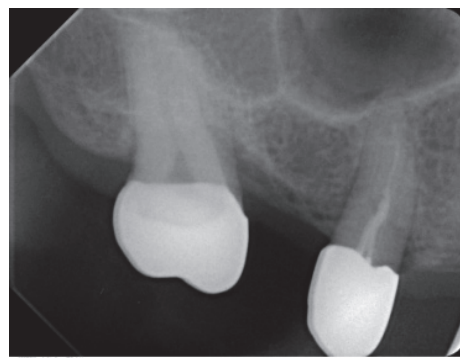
A periapical radiogram shows high septum in the sinus. The bone around septum is dense, so the breaking of sinus floor using OMSFE technique is time consuming and could be traumatic to internal ear due to heavy striking of mallet. Therefore PISE is applied to break sinus floor directly.
